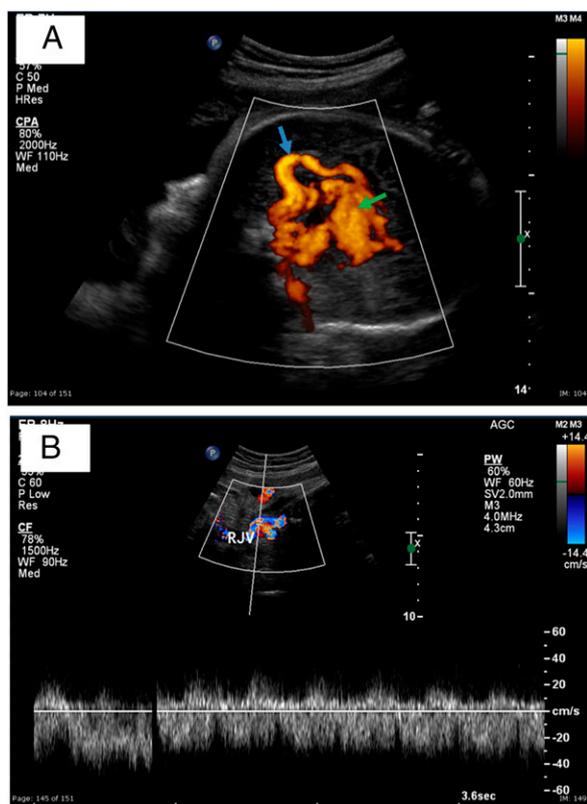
Fetal survey at 37 weeks’ gestation. A. Vein of Galen malformation (VOGM) appears as a tangle of vessels confirmed on color Doppler ultrasonography as an arteriovenous shunt with multiple feeding arteries (blue arrow) that drain into the dilated venous sac (green arrow). B. VOGM causes dilation of blood returning to the right heart. Color Doppler ultrasonography shows dilated right jugular vein with turbulent flow.
